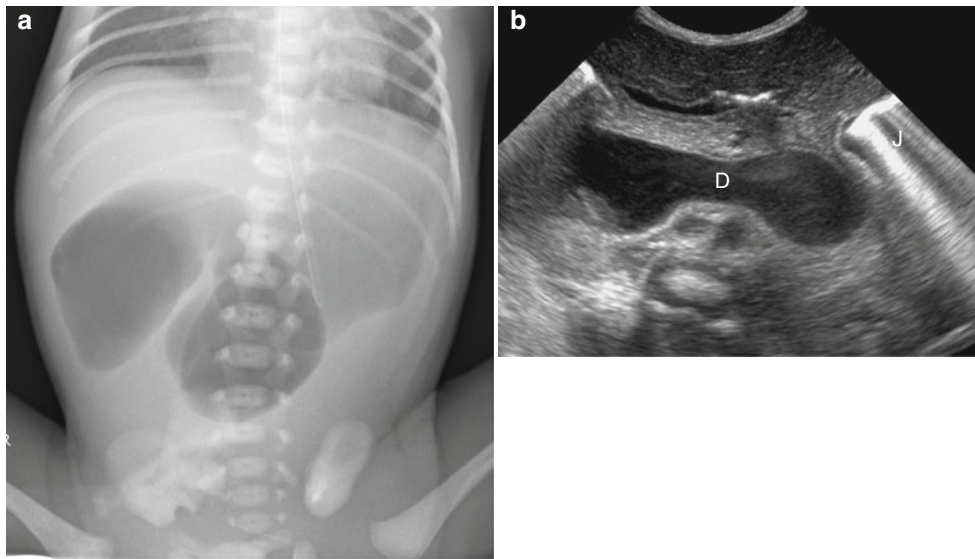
Proximal jejunal atresia in a 1-day-old premature with pre-natal diagnosis of duodenal atresia. (a) Abdominal radiograph demonstrates gaseous distension of the stomach, duodenum, and proximal
